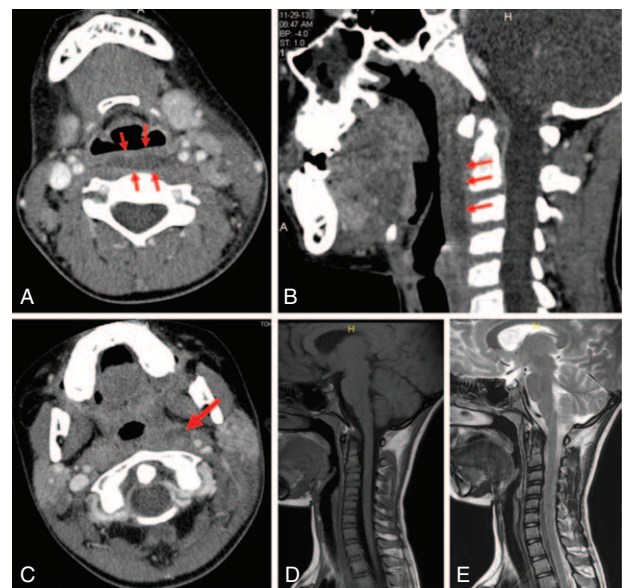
(A) Contrast-enhanced CT examination of the neck in axial plane shows hypodense retropharyngeal collection (arrows). Sagittal reformatted CT image (B) better shows the craniocaudal extension of the abscess (arrows). A necrotic lymph node (arrow in C) is also seen on the left of the neck. Follow-up MRI examination, T1-(D) and T2-weighted (E) sagittal plane images reveal that the lesion was completely resolved after IVIG treatment. CT = computed tomography, IVIG = intravenous immunoglobulin, MRI = magnetic resonance imaging.
